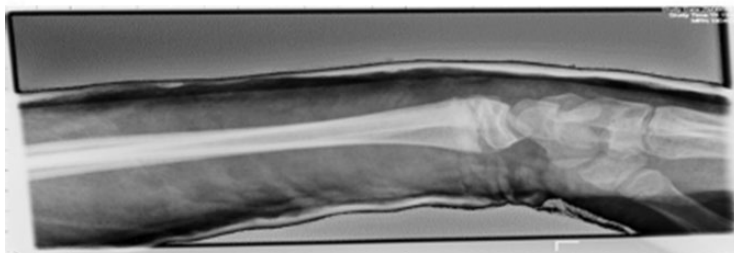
(a–d) The sequence of imaging during the reduction of a Salter–Harris type 2 distal radial fracture. (a) X-ray of fracture (b) US, same fracture (c) US, post reduction (d) X-ray, post reduction.
